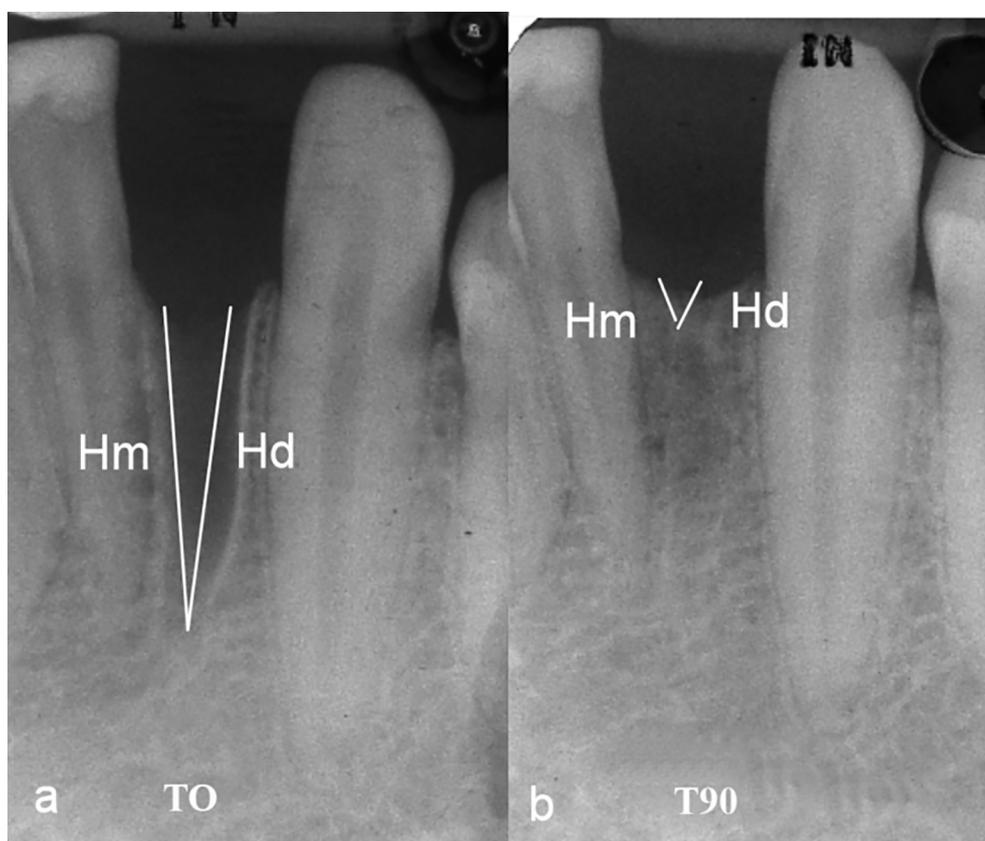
NBH was assessed on standardized periapical radiograph from bone mesial and distal margins of the empty socket to the apical extent of the socket depth. NBH is an average calculated according to the formula: $NBH = (Hm + Hd) / 2$. NBH = New Bone Height; Hm = Height mesial and Hd = Height distal. a: at T0 and b at T90.
